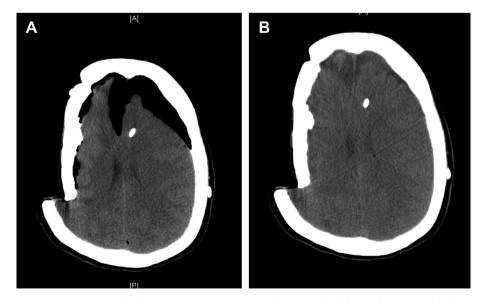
(A) Brain computed tomography showing tension pneumocephalus in both frontal regions. (B) Computed tomography 10 days later demonstrated good resolution of tension pneumocephalus.
